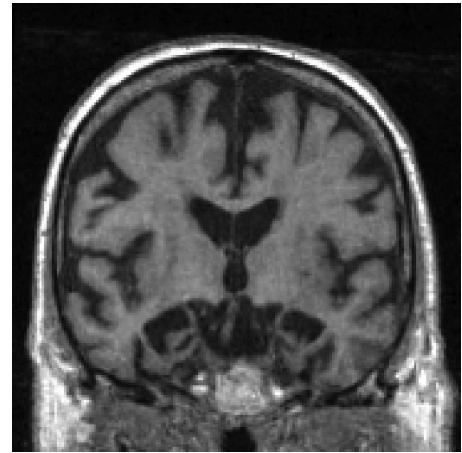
Magnetic resonance imaging (MRI) of classic Alzheimer's disease (AD). Coronal T1-weighted brain MRI of a 72-year-old right-handed man with memory problems for at least 4 years showing bilateral hippocampal, and less severe frontal and temporal cortical, atrophy. Orientation is radiologic (*right* side of figure is left side of brain). (From Sha and Rabinovici 2016, reprinted, with permission, from John Wiley and Sons.)
